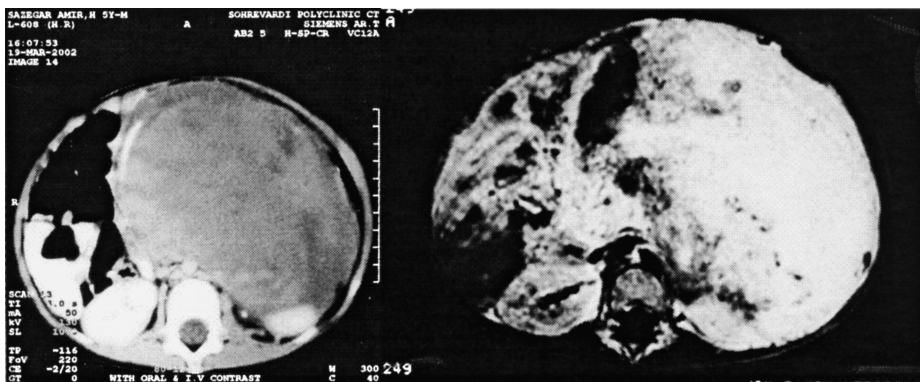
Abdominal CT scan and MRI before chemotherapy.
